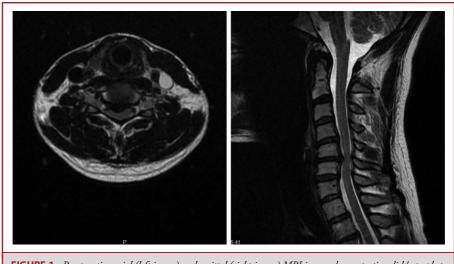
Preoperative axial (left image) and sagittal (right image) MRI images demonstrating disk/osteophyte complex causing severe stenosis at the cervical 5/6 level.
